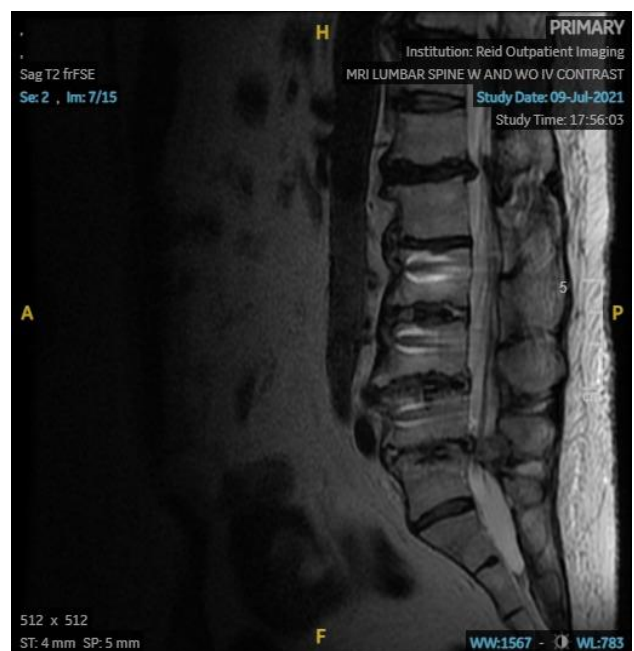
T2 weighted MRI showed no abnormal areas of enhancement are appreciated to suggest an acute infectious process. Irregularity involving the superior endplate of T11 could represent a compression fracture without significant height loss. Difficult to determine acuity. No STIR series was obtained. Disc protrusion and disc osteophytes T12-L1 results in significant spinal canal stenosis. Post-operative changes are present at the posterior lateral left side L5 level; however, this is chronic in nature. This is not an acute process.
